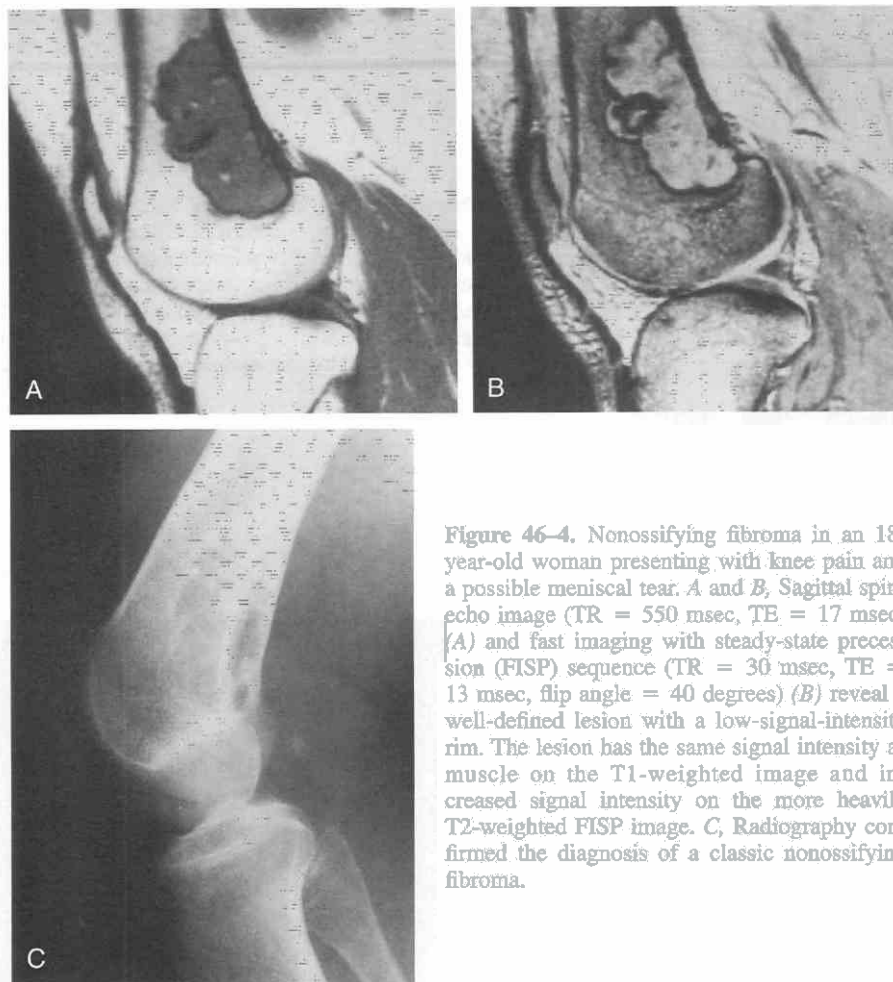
Nonossifying fibroma in an 18-year-old woman presenting with knee pain and a possible meniscal tear. *A* and *B*, Sagittal spin-echo image (TR = 550 msec, TE = 17 msec) (*A*) and fast imaging with steady-state precession (FISP) sequence (TR = 30 msec, TE = 13 msec, flip angle = 40 degrees) (*B*) reveal a well-defined lesion with a low-signal-intensity rim. The lesion has the same signal intensity as muscle on the T1-weighted image and increased signal intensity on the more heavily T2-weighted FISP image. *C*, Radiography confirmed the diagnosis of a classic nonossifying fibroma.
